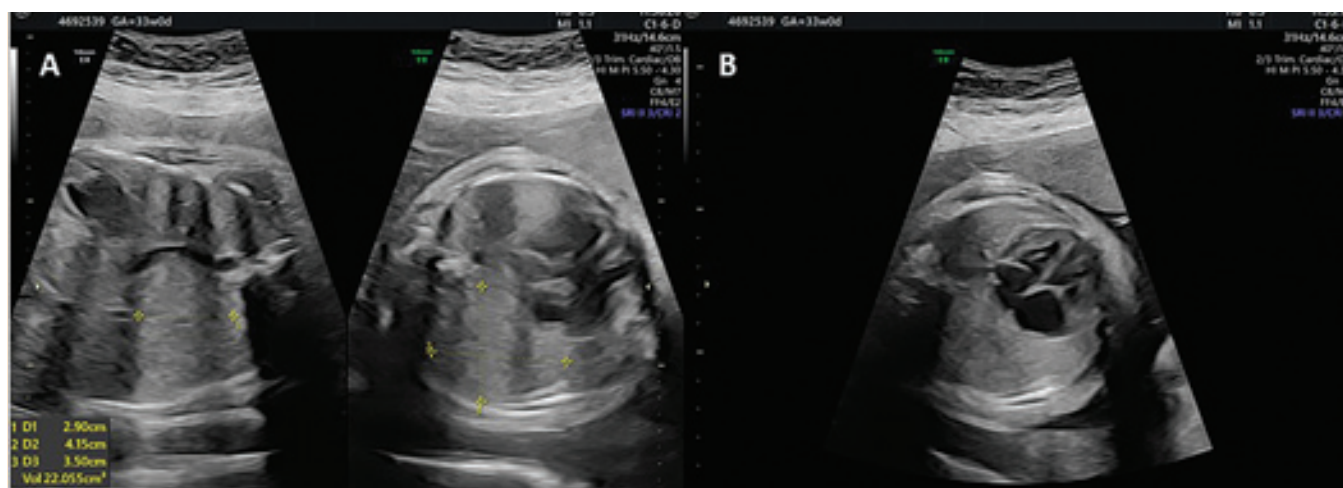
Obstetrical ultrasounds at 23 weeks and 1 day (A) and 26 weeks (B), respectively, at thorax level in axial and sagittal views showing the congenital cystic adenomatoid malformation volume calculation after corticosteroid therapy.
